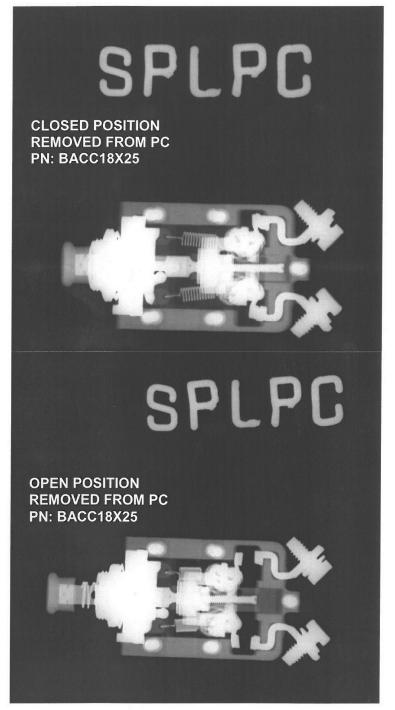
X-ray picture of C829 circuit breaker
